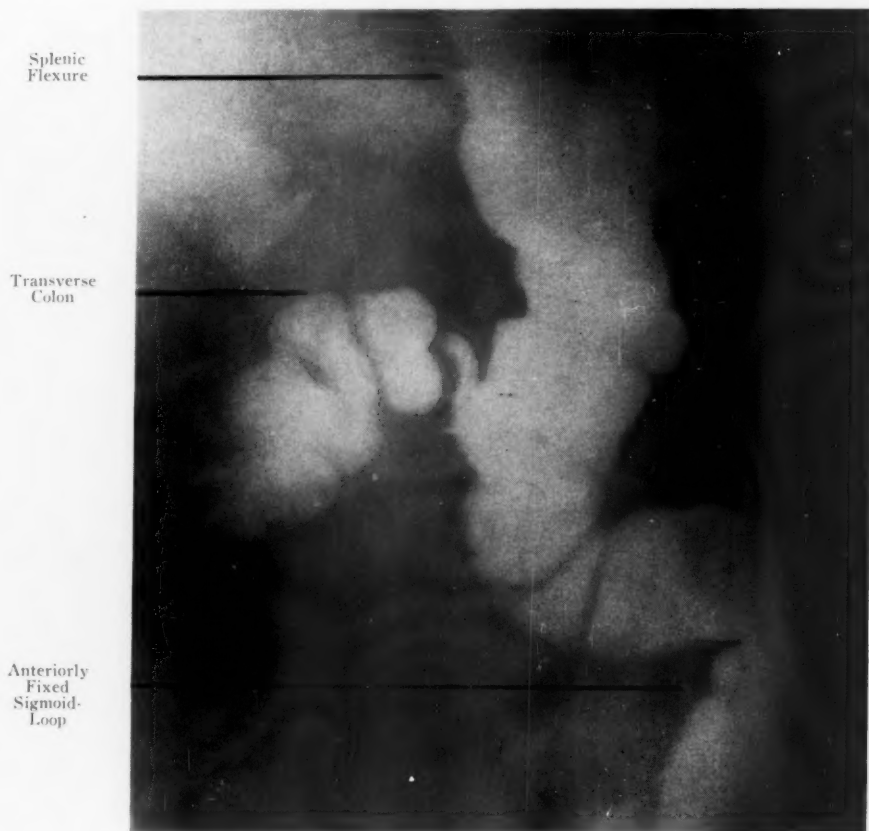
Case 1: Lateral roentgenogram showing the anterior fixation of the sigmoid loop, postoperatively.
